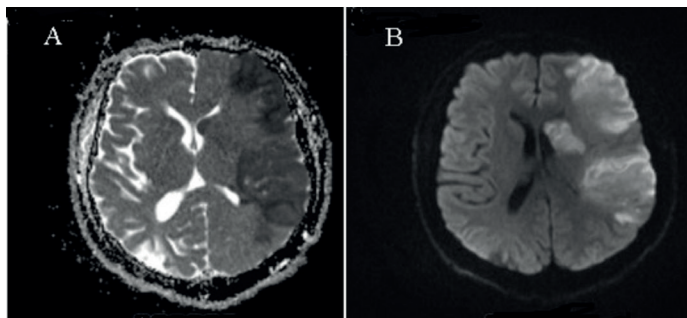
Left middle cerebral artery infarction. (A) ADC map, (B) diffusion-weighted magnetic resonance imaging
